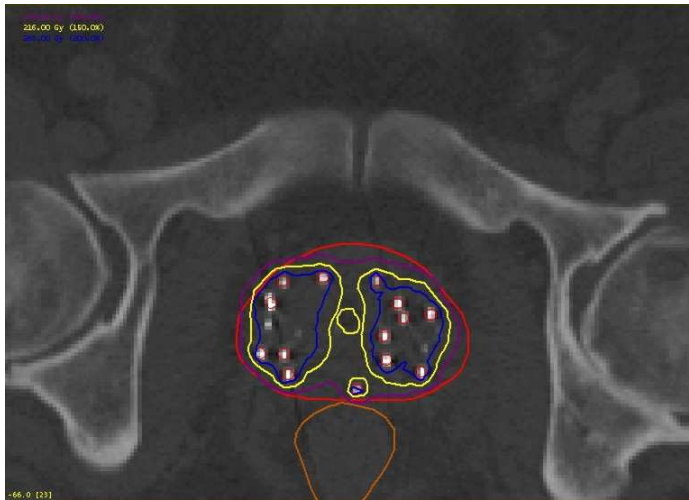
Prostate cancer – Scan made on next day after permanent seeds implantation. Example of CT-dosimetry after application in Greater Poland Cancer Centre. Prostate is underlined with red line, violet line presents the 100% isodose, yellow line – 150% and blue – 200%, respectively. Urethra (yellow in the middle of prostate) and rectum (brown line) are marked too. Seeds are clearly visible.
